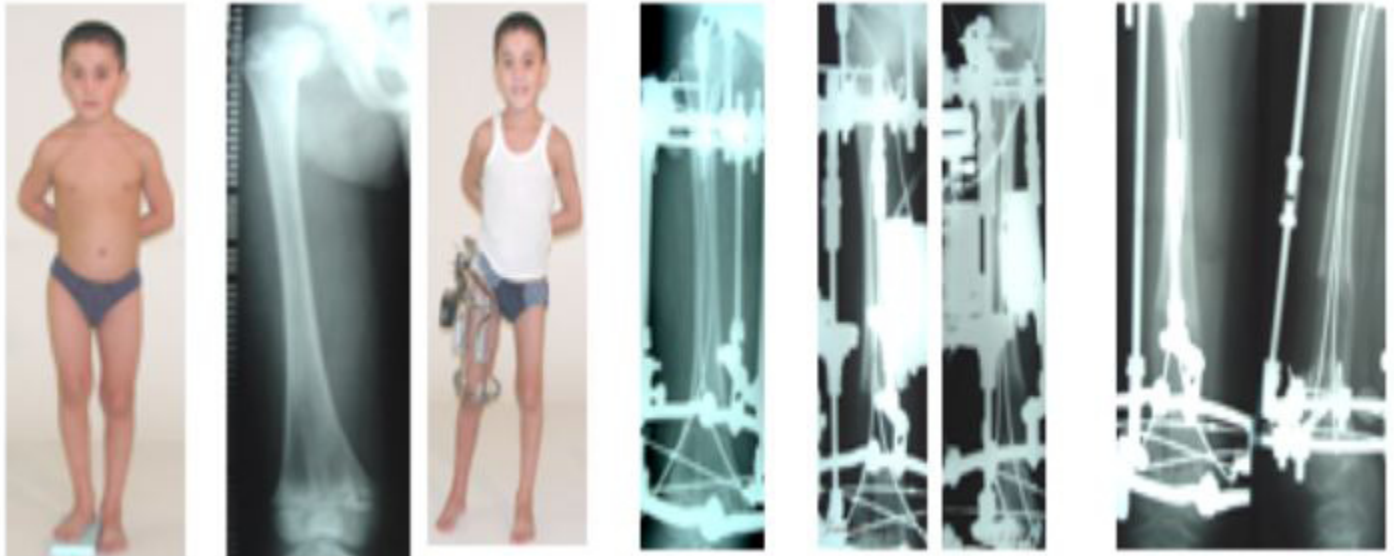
Photo and X-rays of patient 7-years-old with consequences of hematogenous osteomyelitis, 5 cm shortening of right leg before and during treatment
